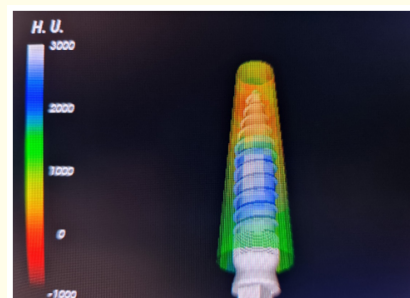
Cone beam computed preoperative assessment of bone density around the implant site.
